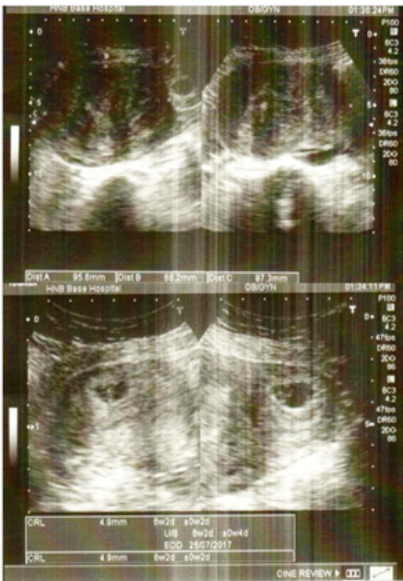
Ultrasound image of a rare cervical ectopic pregnancy of 8 weeks gestation.
